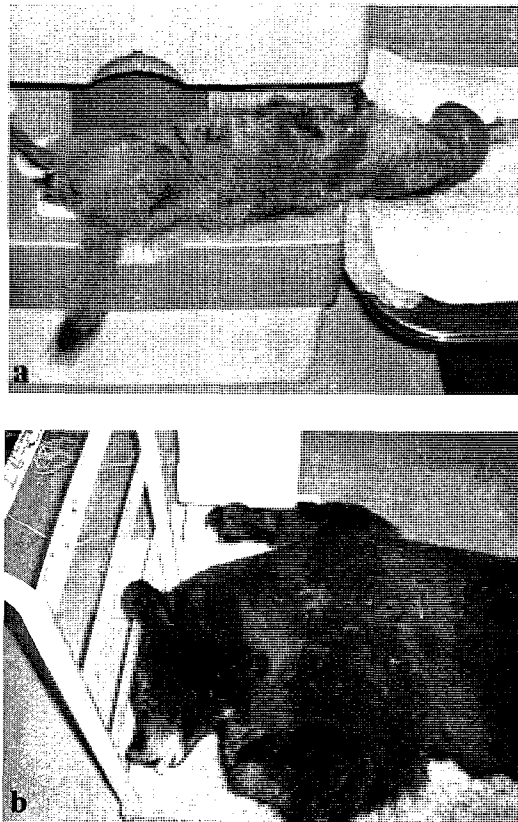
Dual Energy X-Ray Absorptiometry (DXA) Analysis of an Arctic Ground Squirrel (*Spermophilus parryii*) and an American Black Bear (*Ursus americanus*). DXA data and images were obtained from the femurs of arctic ground squirrels (*Spermophilus parryii*) (a) and the middle phalynxes of American black bears (*Ursus americanus*) (b).
